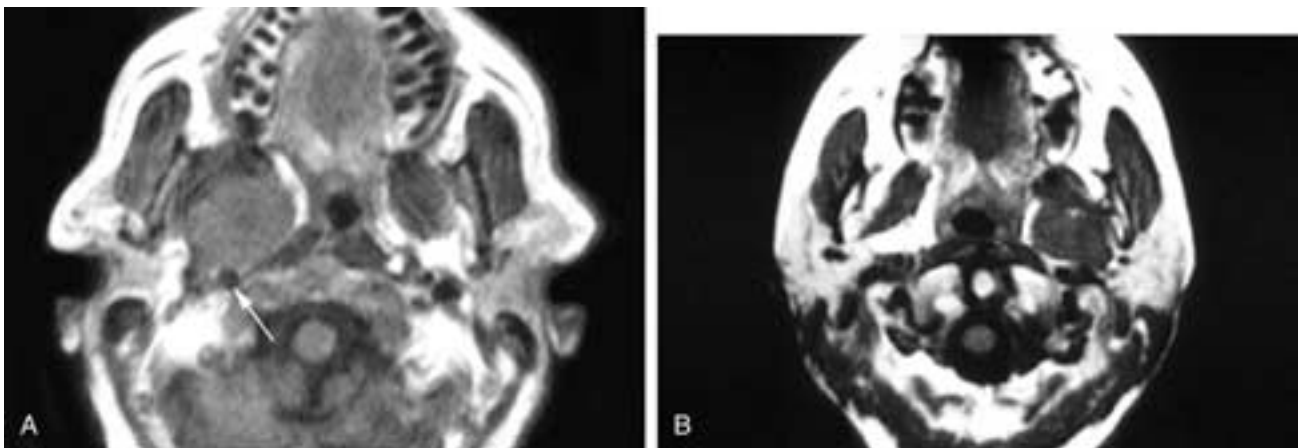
Axial T1-weighted MR image (A) shows an ovoid mass in the right prestyloid parapharyngeal space fat. A fat plane is present along its medial side, separating it from the pharyngeal constrictor muscles. A fat plane also separates the mass from the parotid gland. This was an extraparotid pleomorphic adenoma arising from minor salivary gland rest cells. The ICA is dorsal to the mass (arrow). A rare schwannoma, usually of the sympathetic chain, can also have this imaging appearance. Axial T1-weighted MR image (B) shows an ovoid mass in the left prestyloid parapharyngeal space fat. Fat planes are present along both its medial and lateral sides, separating it from the pharyngeal constrictor muscles and the parotid gland. The mass is ventral to the ICA. This was an extraparotid pleomorphic adenoma.
